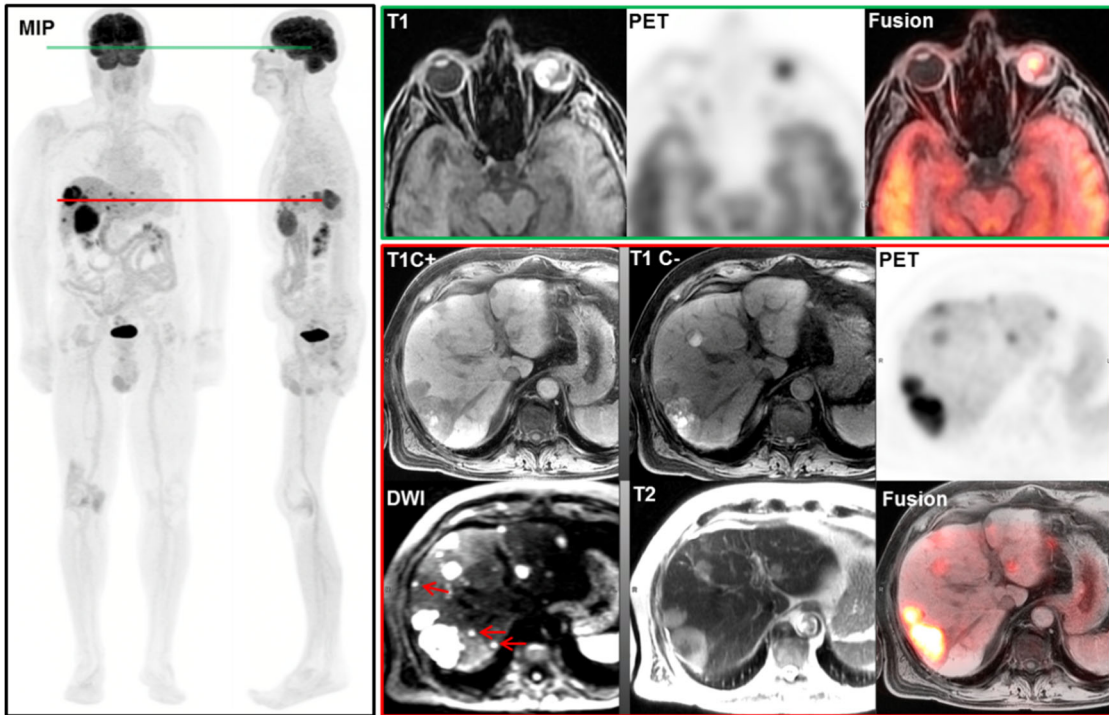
Whole body hybrid FDG-PET/MR in surveillance of uveal melanoma (case #1). Whole body MIP images exhibit tracer avid left eye lesion and numerous tracer avid lesions in the liver. Axial PET/MRI of the left eye demonstrates high T1-signal lesion in the left globe with increased tracer uptake, with SUV max 8.3 (green line, green box). On the representative layer of the liver (red line, red box), multiple liver lesions with variable low and high T1 signals show increased uptake, with SUV max 4.0-11.7. In addition, DWI shows more small metastases with restricted diffusion (red arrows) than post-contrast enhanced images (T1C+) and PET. DWI, diffusion-weighted imaging; MIP, maximal intensity projection.
